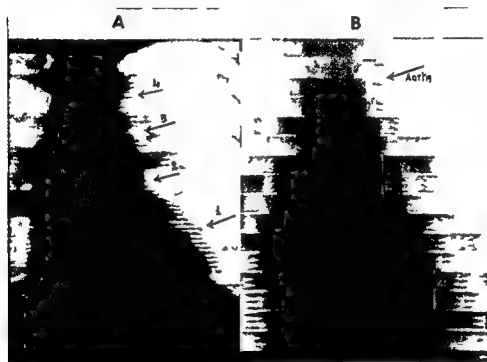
Roentgenkymograms (A) System with moving slits (B) System with moving film
